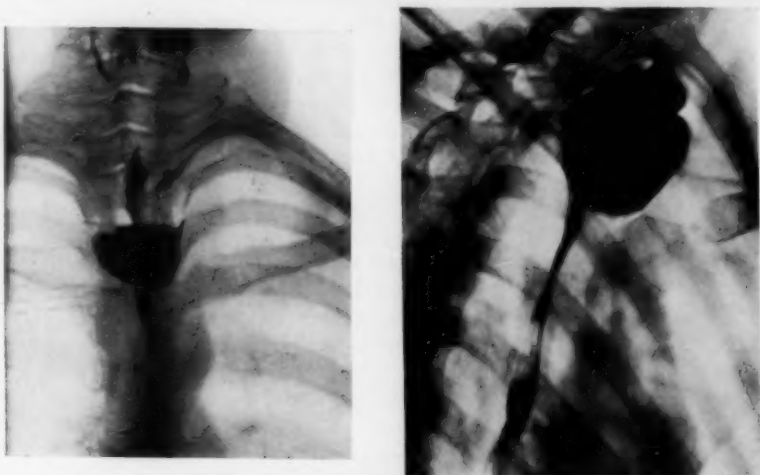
Roentgenograms made in the P-A and lateral planes in a case of cicatricial stenosis of the esophagus. There is a history of swallowing lye when a child. The case was considered as one of pulsion diverticulum of the pharynx. The lateral Roentgenogram shows the esophagus coming off the fundus of the pouch instead of being anterior to it, as in the case of diverticulum. By esophagoscopy the true nature of the condition was clearly demonstrated.
